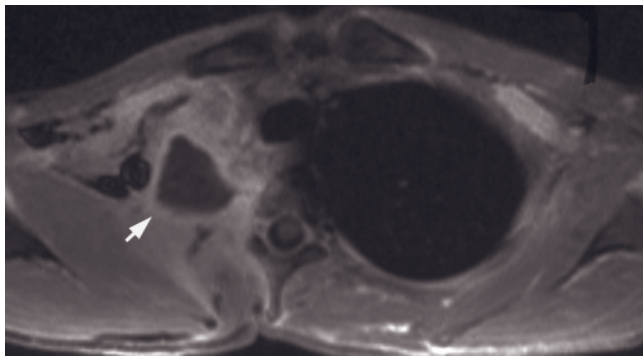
Pleural disease. T2-weighted fat-suppressed ETSE image (a) demonstrates complex pleural effusion with numerous low-signal regions (arrows). In a second patient, T2-weighted fat-suppressed ETSE (b) and postgadolinium fat-suppressed 3D-GE (c) images show bilateral pleural effusions. Split pleura sign is well demonstrated on postgadolinium image (arrows, c). T2-weighted
